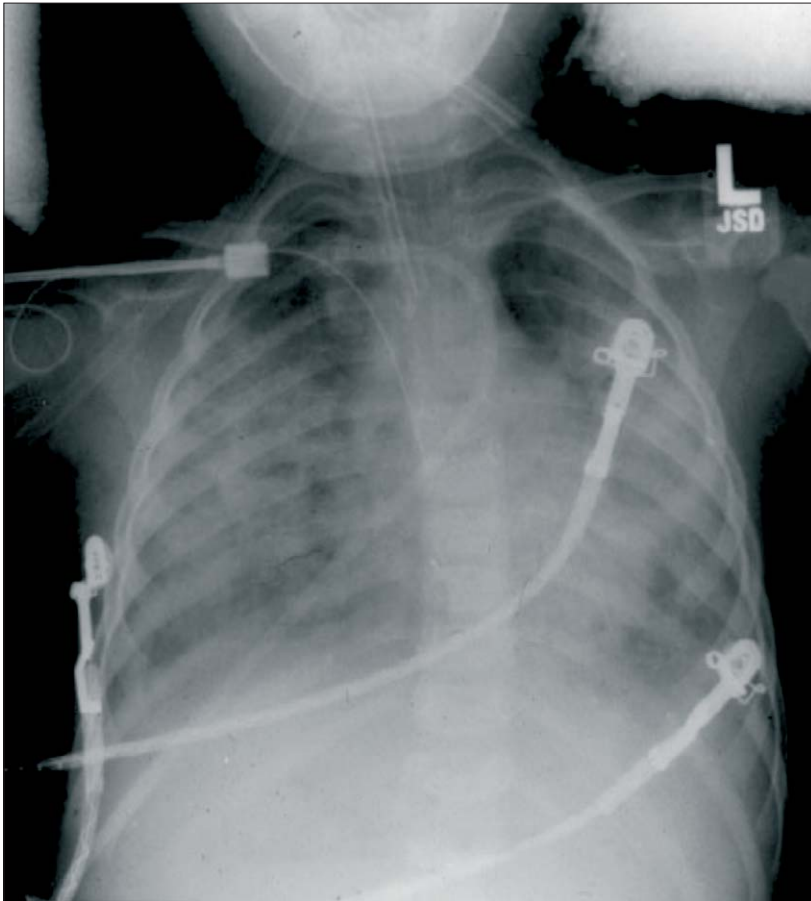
Frontal portal chest radiograph showing diffuse bilateral infiltrates consistent with acute lung injury
